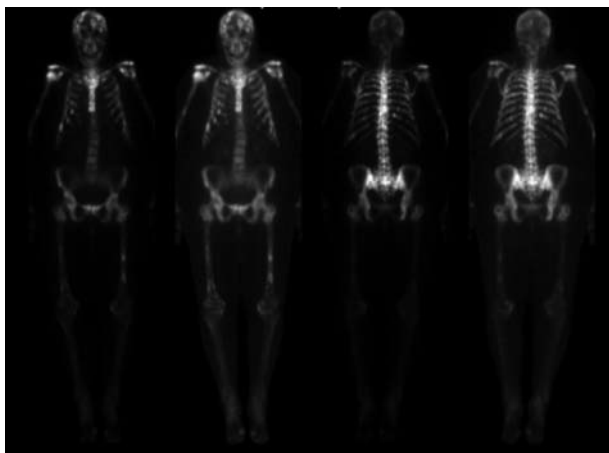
Bone scintigraphy showing multiple bone metastases.
